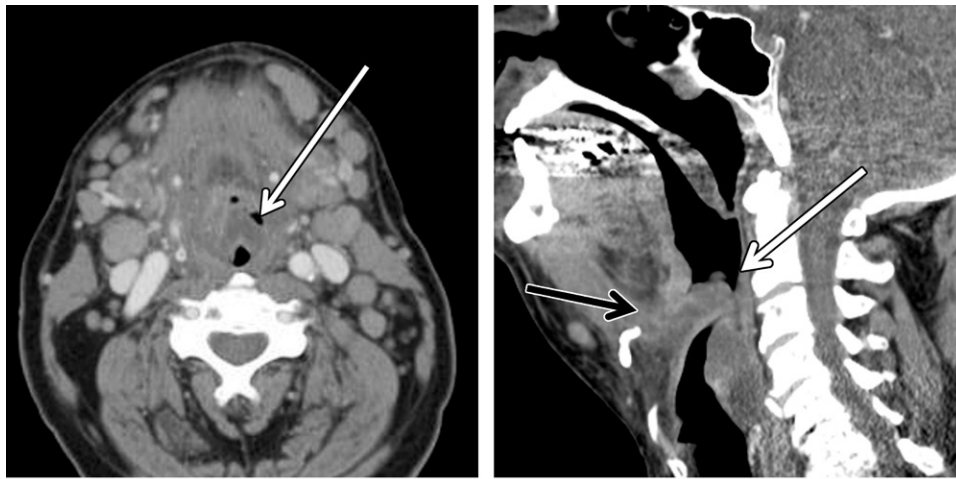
Acute epiglottitis in a 70-year-old man with a sore throat for 3 days and progressive odynophagia. Axial (a) and sagittal (b) CT images show an enlarged and edematous epiglottis (white arrow) with mucosal enhancement and some stranding of the adjacent supraglottic larynx and tongue base (black arrow in b). Substantial airway narrowing is present.
